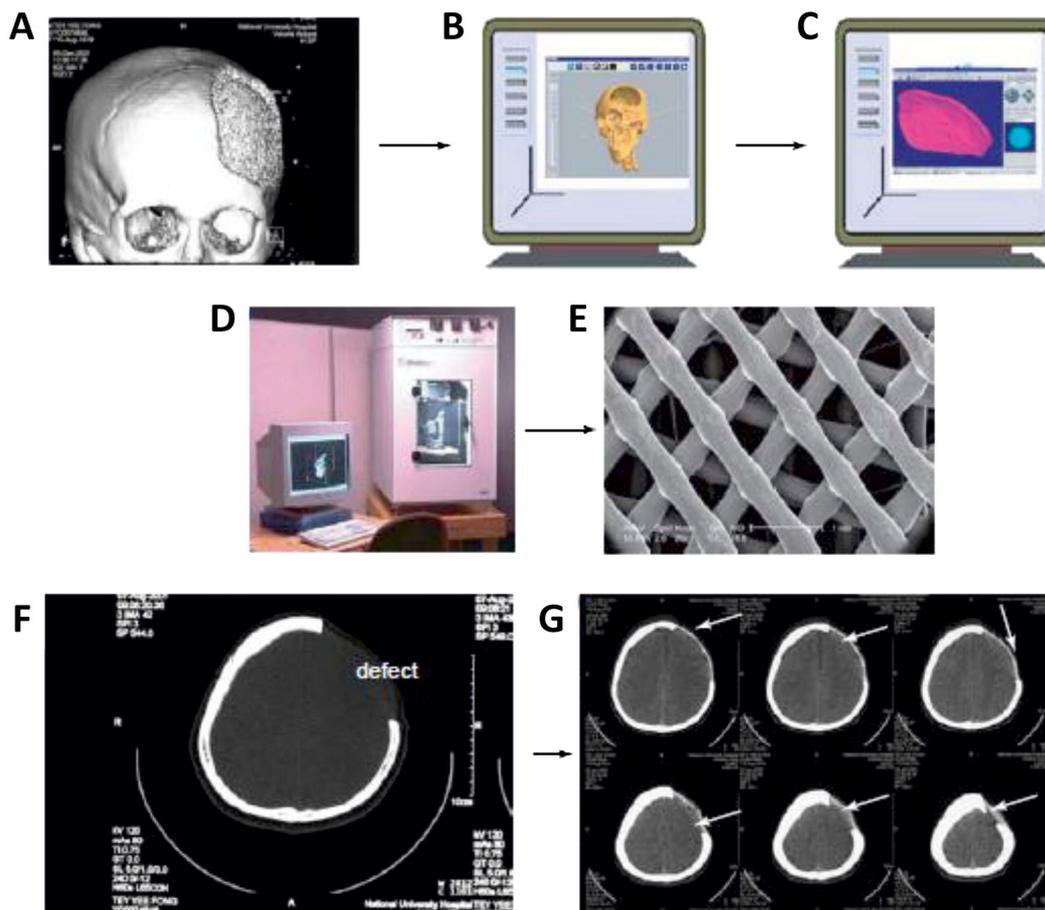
Development of patient-specific bone graft substitutes by combining medical imaging, computational modelling and rapid prototyping (RP). CT scan data of the patient's bone defect (A) are used to generate a computer-based 3D model (B). This model is then imported into RP system software to be 'sliced' into thin horizontal layers, with the tool path specified for each layer (C). The 'sliced' data are used to instruct the RP machine (D) to build a scaffold (E) layer by layer, based on the actual shape of the computer model (C). RP technology produces excellent templates for the treatment of intricate bone defects (A, F). Custom-made constructs (G, see arrows) exactly follow the complex shaped 3D contour of the skull. Reprinted with permission from Hutmacher *et al.* (2004)
